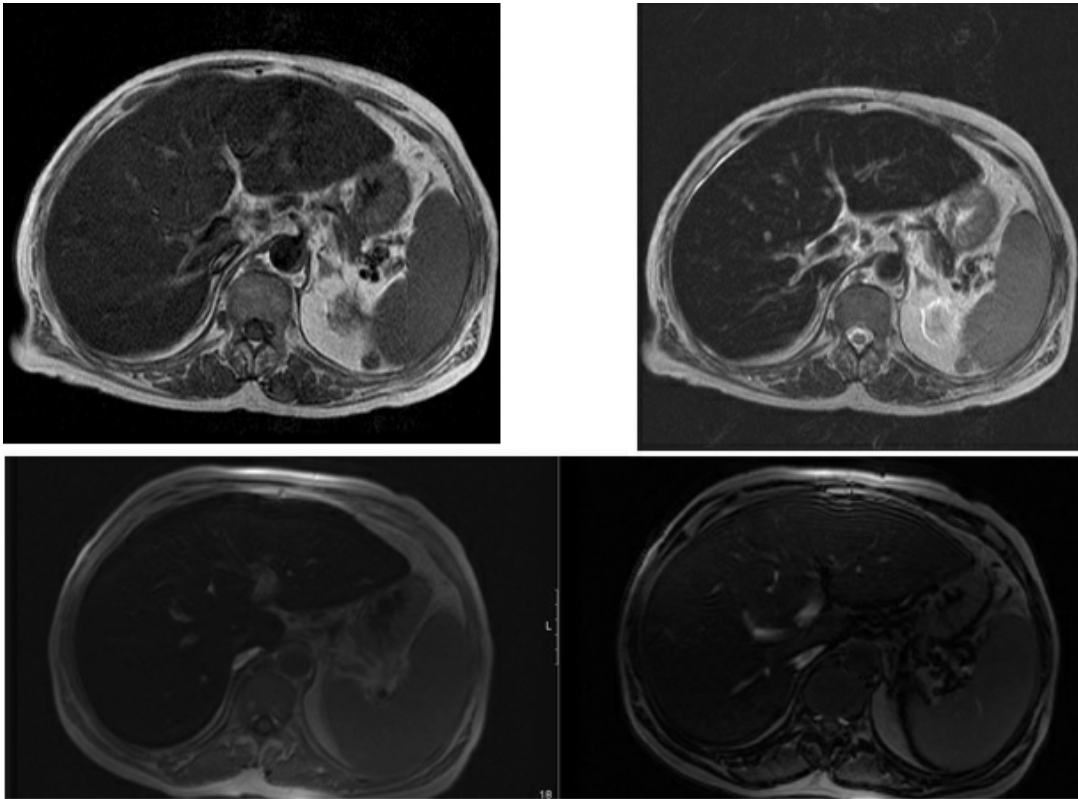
MRI documenting in axial T1-weighted (upper left) and T2-weighted (upper right) images a decrease in the liver signal intensity. Axial T1-weighted gradient echo sequence images (lower panel) show a decreased signal intensity in the liver on the in-phase image (left) compared with the out-of-phase image (right), corroborating hepatic iron overload.
